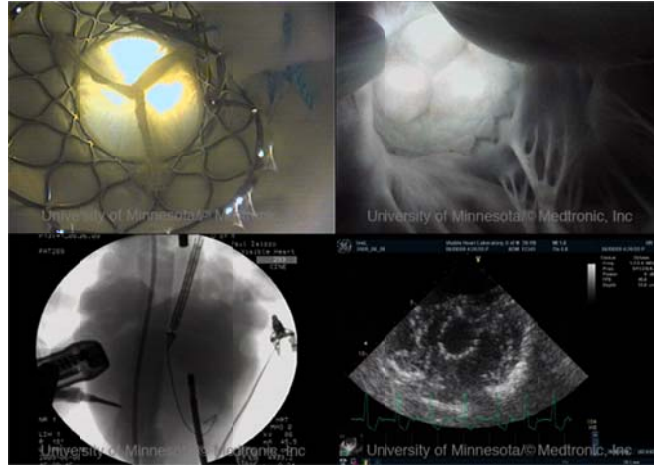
A transcatheter delivered aortic valve imaged using: 1) an endoscope placed within the ascending aorta (upper left panel); 2) an endoscope placed within the left ventricle (upper right panel); 3) fluoroscopy with an anterior-posterior orientation (lower left panel); and 4) ultrasound (lower right panel). Modified from Iazzo et al. [21].
